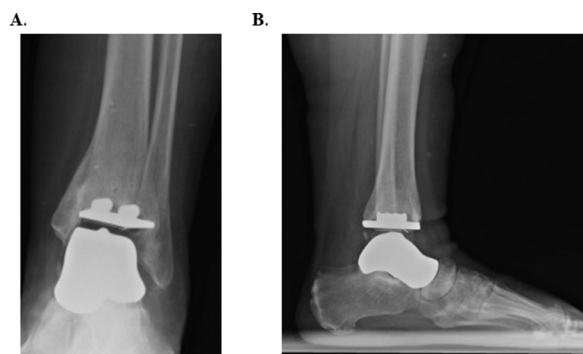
Plain Radiographs of TATTR components at 1-year follow-up. Postoperative standing AP (A) and lateral (B) plain radiographs of the left ankle. The TATTR components were well-positioned without evidence of failure
